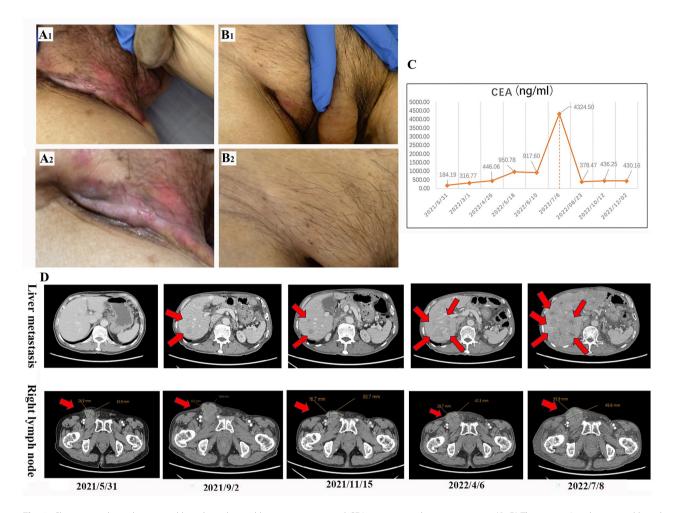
Changes in the right inguinal lymph nodes and liver metastases and CEA expression during treatment. (A, B) The patient's right inguinal lymph nodes shrank significantly, and the ulcer healed (A1, A2. Before treatment: May 2021; B1, B2. After treatment: November 2021). (C) Changes in carcinoembryonic antigen (CEA) levels during treatment. (D) Changes in the right inguinal lymph nodes and liver metastases on abdominal CT during treatment. The patient refused all CT scans and only underwent ultrasound examinations after July 2022
